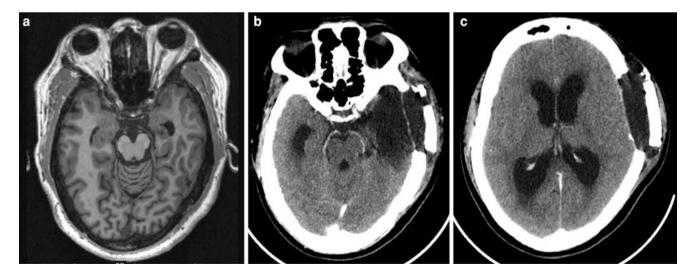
In a 31-year-old man with a long history of epilepsy, preoperative magnetic resonance imaging demonstrated atrophy of the left hippocampus, suggestive of mesial temporal sclerosis (a). Anterior temporal lobectomy with amygdalohippocampectomy was done, but
